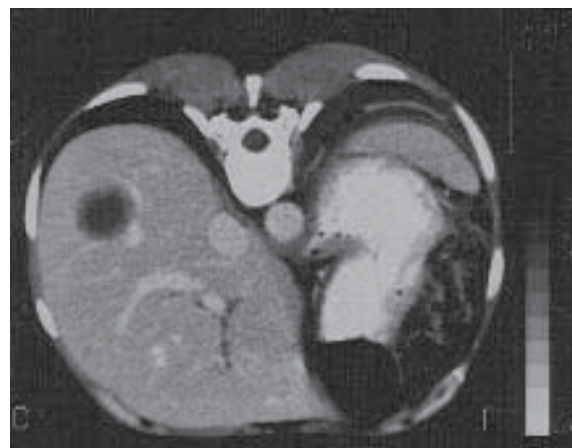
CT scans showing a heterogenous lesion in Rt lobe of liver suggesting metastasis
